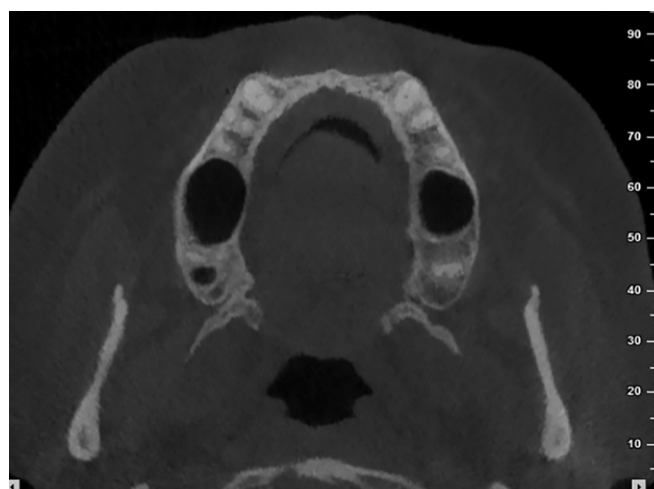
Cone beam computed tomography at the time of initial presentation
